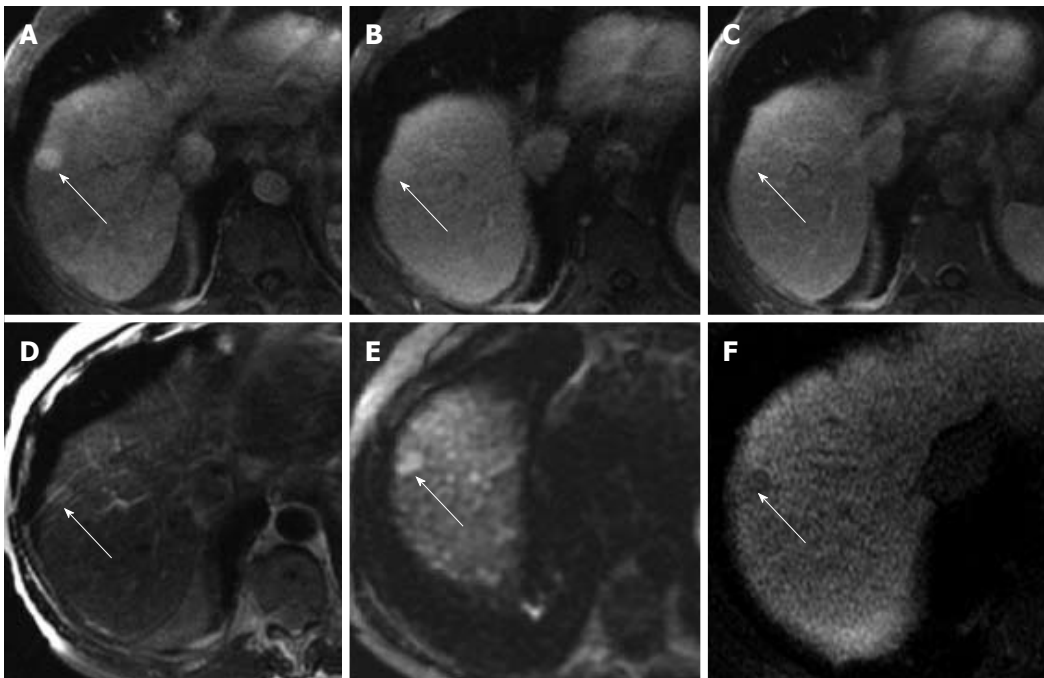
An initial study was performed using Gd-DTPA. This showed an arterially-enhancing lesion (A) with no evidence of wash-out or pseudocapsule on the portal venous (B) or delayed (C) phases with hyperintensity on T2W (D) and DWI (E) sequences. A follow-up study acquired two months later with Gd-EOB-DTPA demonstrated a hypointense lesion on the hepatobiliary phase (F), increasing diagnostic confidence of hepatocellular carcinoma.
